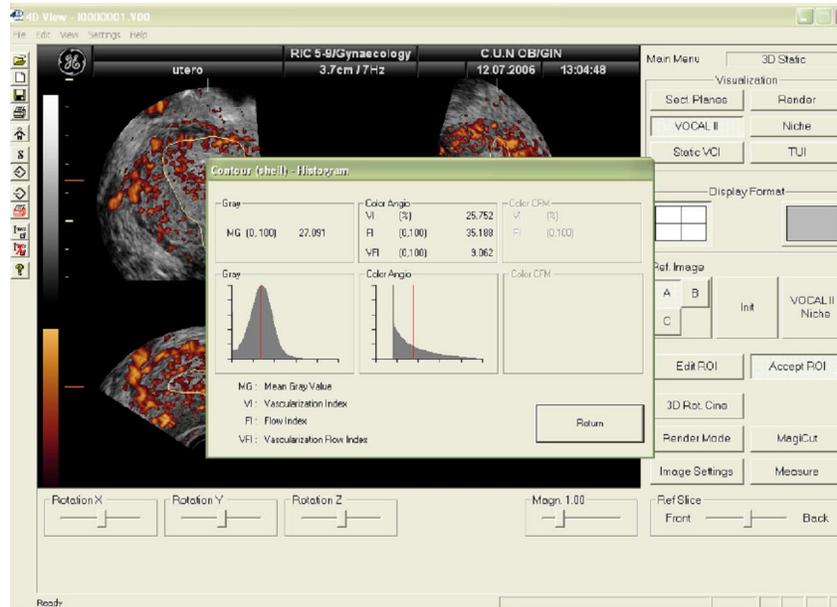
Endometrial volume calculation by using the VOCAL software after three-dimensional ultrasound (Alcazar, 2006).
